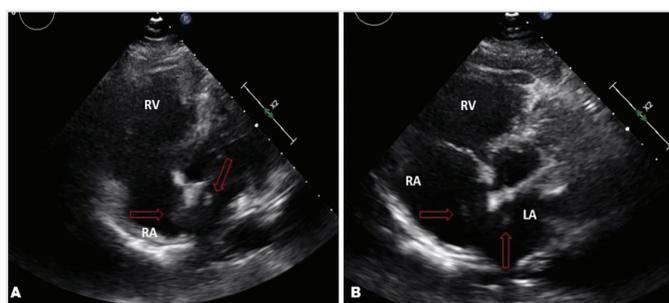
Transthoracic echocardiography demonstrating hyperechogenic density images of a trapped thrombus image in the interatrial septum with enlargement of the right ventricle and the right atrium (A, B)
